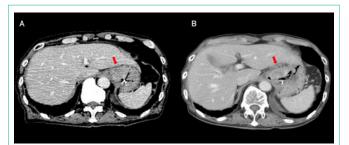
Temporal changes on abdominal computed tomography (CT) for case 1. (A): CT findings before treatment: CT revealed a bulky recurrent tumor on the gastric cardia. (B): CT findings 1 month after treatment: the bulky tumor was flat and reduced. * The red arrows point to the tumor.
